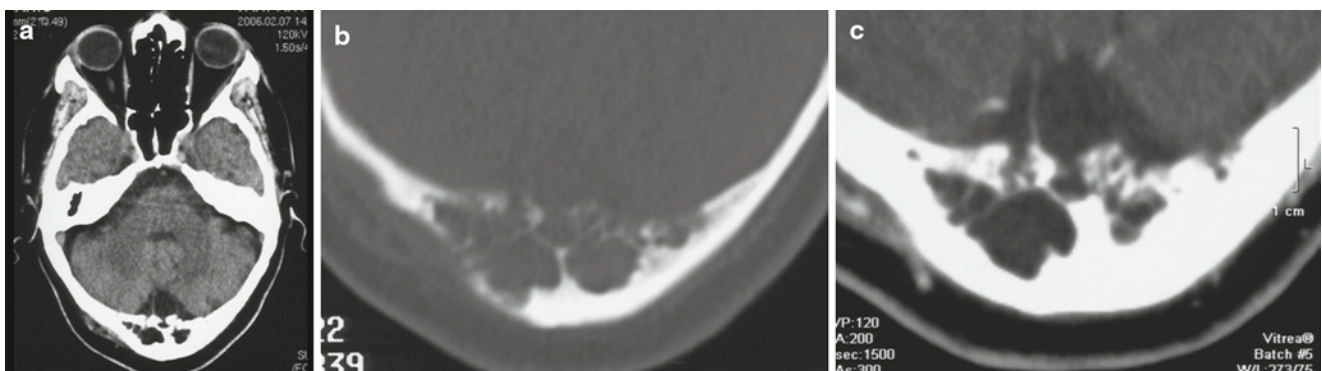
Axial CT scan shows a hypodense osteolytic lesion of the occipital protuberance (a); bone window reconstruction highlights the erosion of both tables of the calvaria due to a hypodense mass (b), after contrast administration no enhancement of the lesion is documented (c)
